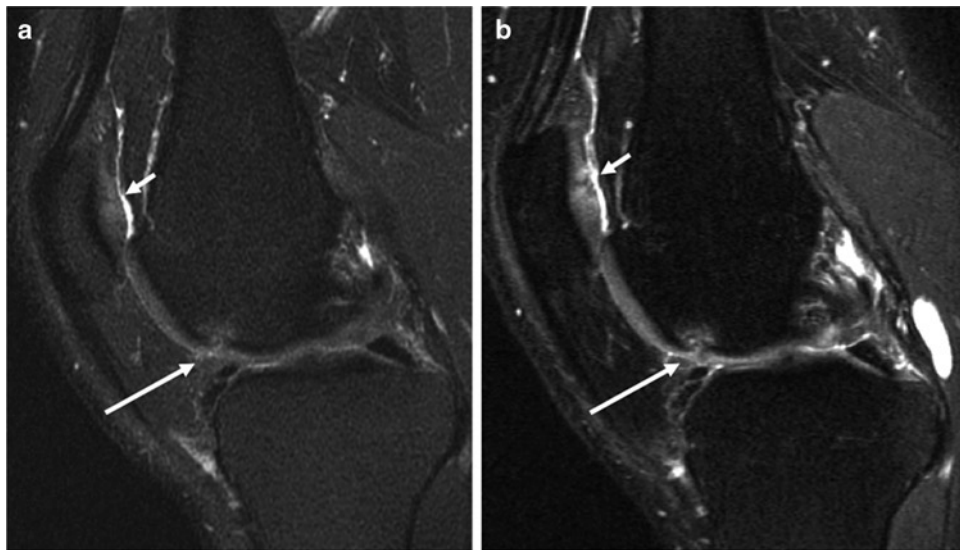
Sagittal MRI of the knee obtained in a middle-aged runner with knee pain at 1.5 T (a) and 3.0 T (b) using fat-suppressed IM-weighted FSE sequences (3,200/46 and 4,300/51 ms). Cartilage
